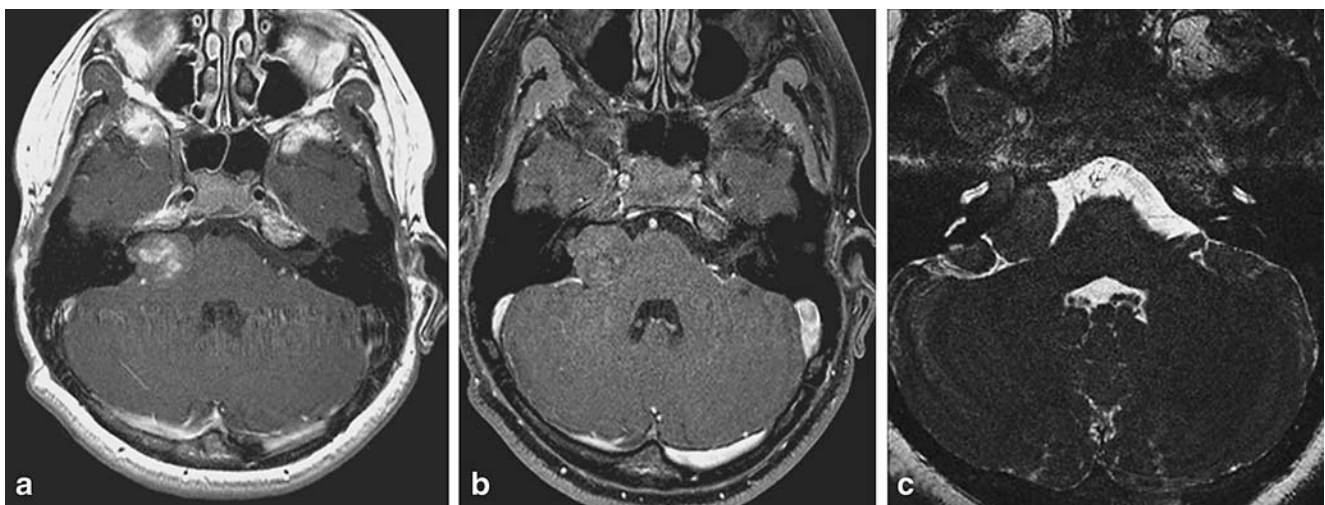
a Noncontrast axial T1-weighted MR image revealing a nonhomogeneously hypointense right CPA tumor. b Same image after contrast enhancement revealing a non enhancing tumor. c A T2-weighted MR image revealing a hypointense in the right CPA cistern
